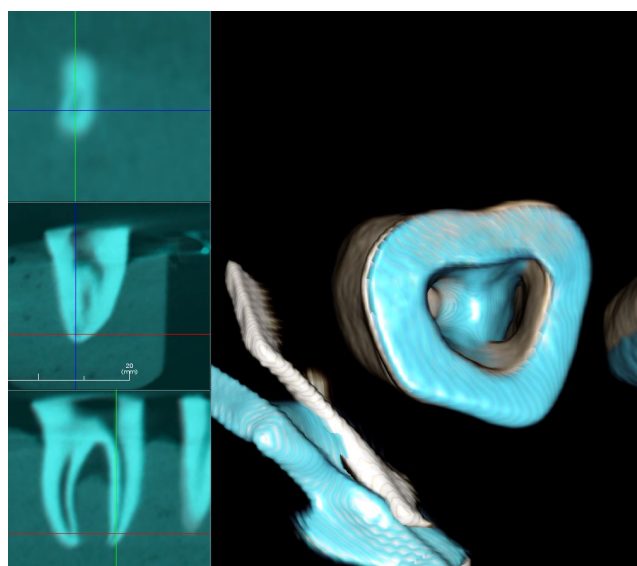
Superimposition Images using CBCT
